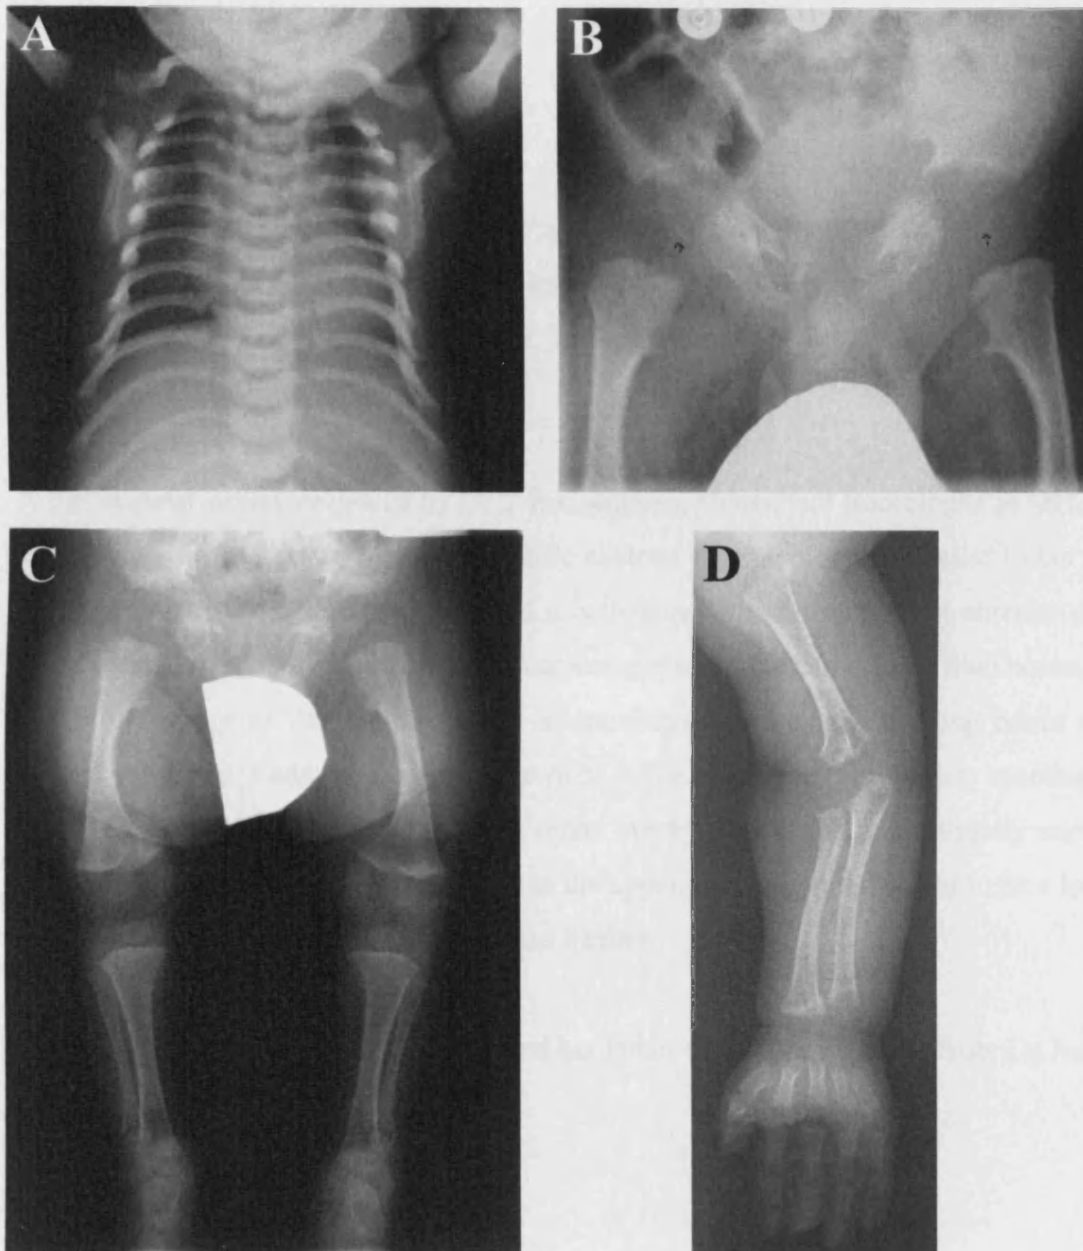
Radiographs of patient II.6 from Family 4. The upper thorax is narrow with short ribs (A). In the pelvis, the acetabulae have a trident appearance with medial and lateral spurs (B). There is shortening of the long bones, bowing of the femora, disproportionate shortening of the fibulae and advanced ossification of the capital femoral epiphyses (C). In the hand, there are coned shaped epiphyses of the middle phalanges (D).
